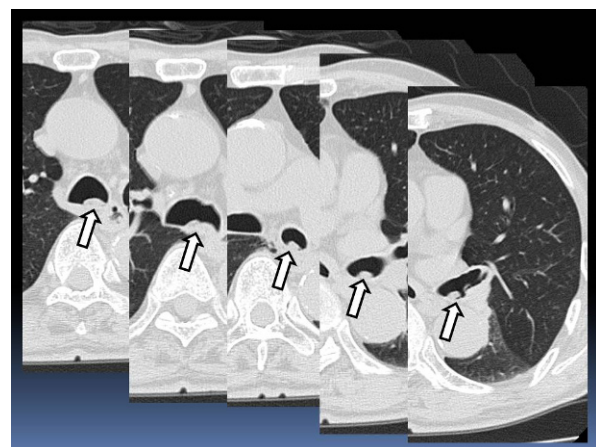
CT scan revealed a mass-like opacity within the lower part of trachea and left main bronchus attached to the posterior wall.
